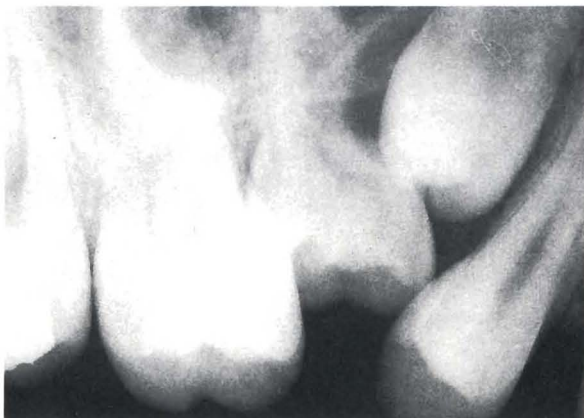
Intraoral periapical radiograph of a thirteen-year-old girl with secondary retention of the left second primary molar in the maxilla.
